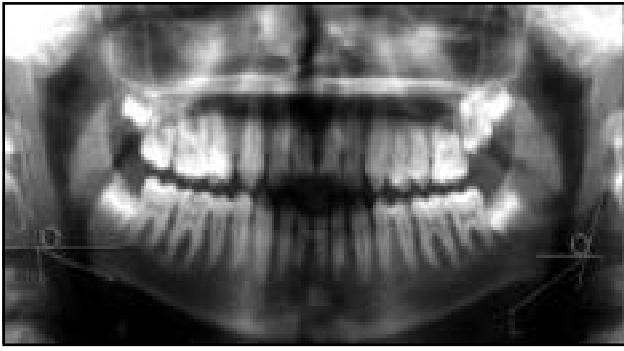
The view of ROIs on left and right mandibular angle on panoramic radiograph. ROI - region of interest
